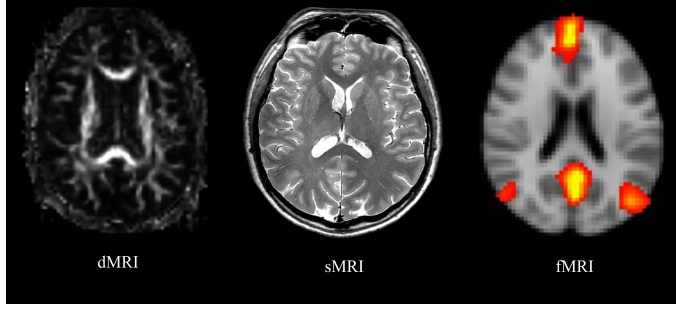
The diffusion, structural and functional MRI. The dMRI is the map of FA. The red spots are for default mode network resting-state network.
